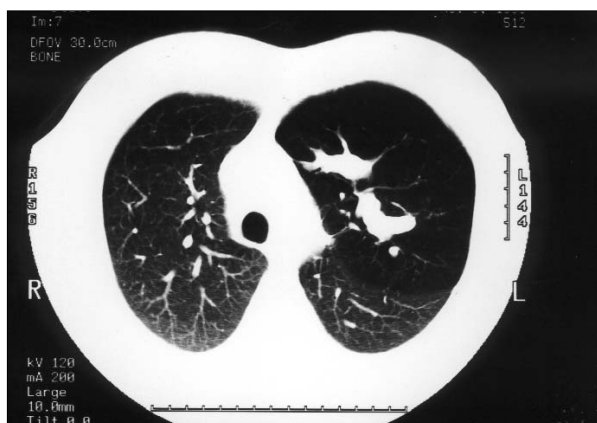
HRCT scan of the chest of the patient presented in case 3, showing the branching mucocoele and the hyperlucency of the left upper lobe anteriorly, along with air trapping and reduction of the size of the pulmonary vessels at the same area.
